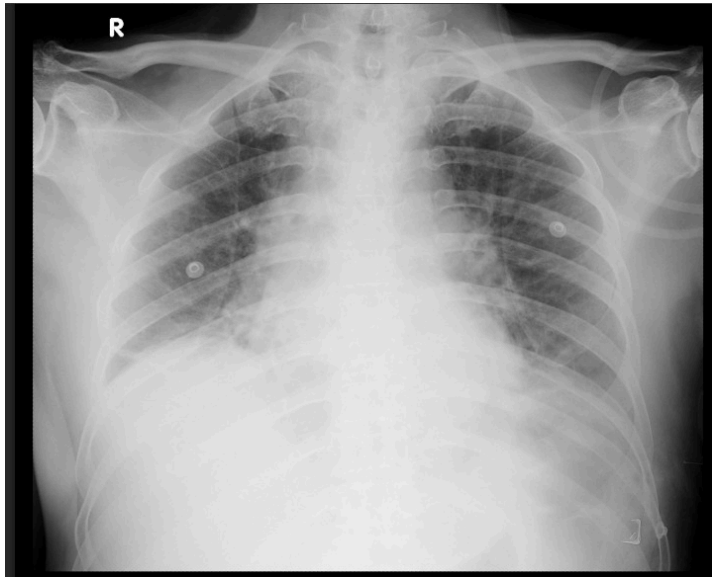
Anteroposterior (AP) Chest X-ray showing bilateral perihilar haziness and infiltrates with air bronchograms, consistent with bilateral pneumonia and pulmonary edema.
